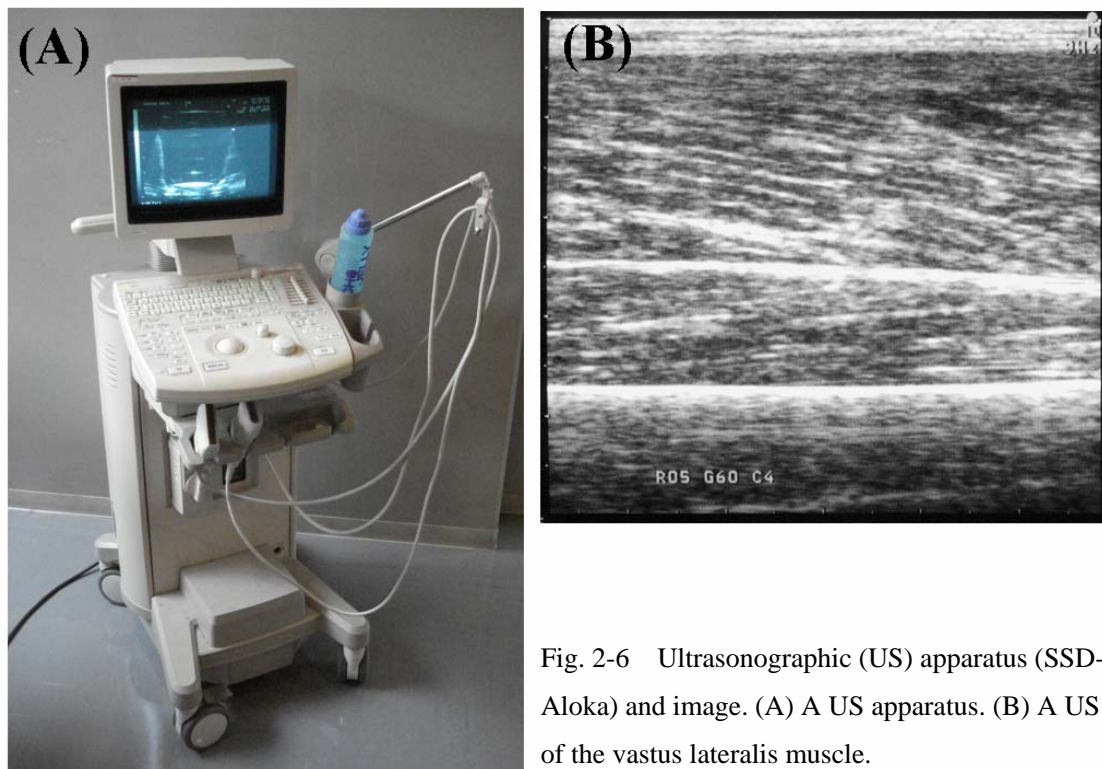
Ultrasonographic (US) apparatus (SSD-1000, Aloka) and image. (A) A US apparatus. (B) A US image of the vastus lateralis muscle.
